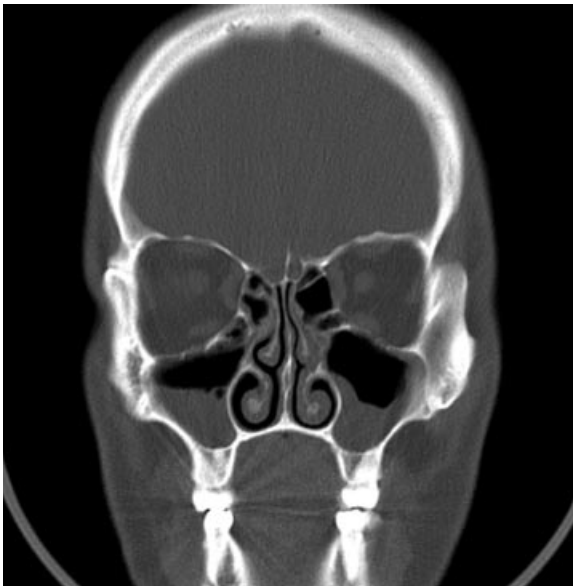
CT in frontal plane – fluid level in the right maxillary sinus (patient in prone position), prominent mucosal thickening in the left maxillary sinus and ethmoid.
